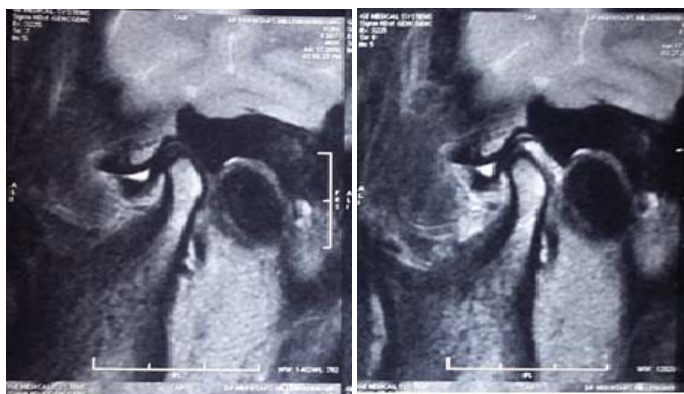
MR image showing Anterior Disc Displacement in closed mouth position and opened mouth position.
